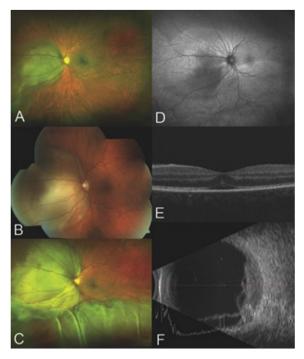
A large raised yellow choroidal lesion is present nasal to and abutting the left optic disc (A). The lesion grew by 4mm (B) and 6mm (C) in diameter 2 and 4 weeks after presentation respectively. The lesion is isoautofluorescent but the areas of subretinal fluid are hyperautofluorescent (D). Optical coherence tomography demonstrates a small amount of subretinal fluid at the macula (E). B-scan ultrasonography shows an echodense tumour measuring 4.0mm in height with overlying and inferior subretinal fluid but no extraocular extension (F)
